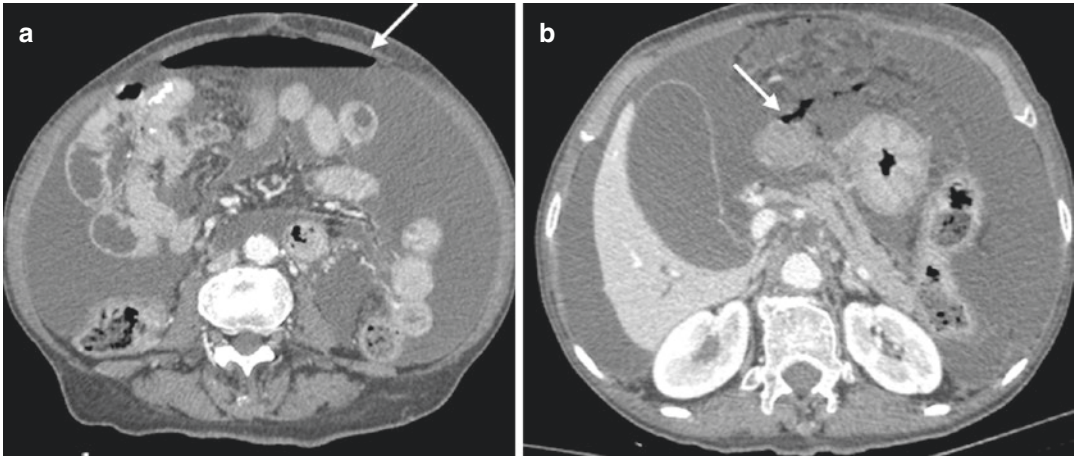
CT of a 75-year-old male with acute abdomen. Note the pneumoperitoneum (a, arrow), due to gastric wall perforation (b, arrow)
